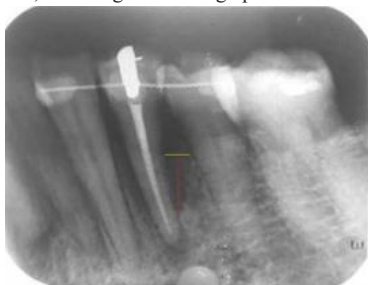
The Vertical Bone Deficit In Respect To #44 Is Seen On The Pre-operative Radiograph.
